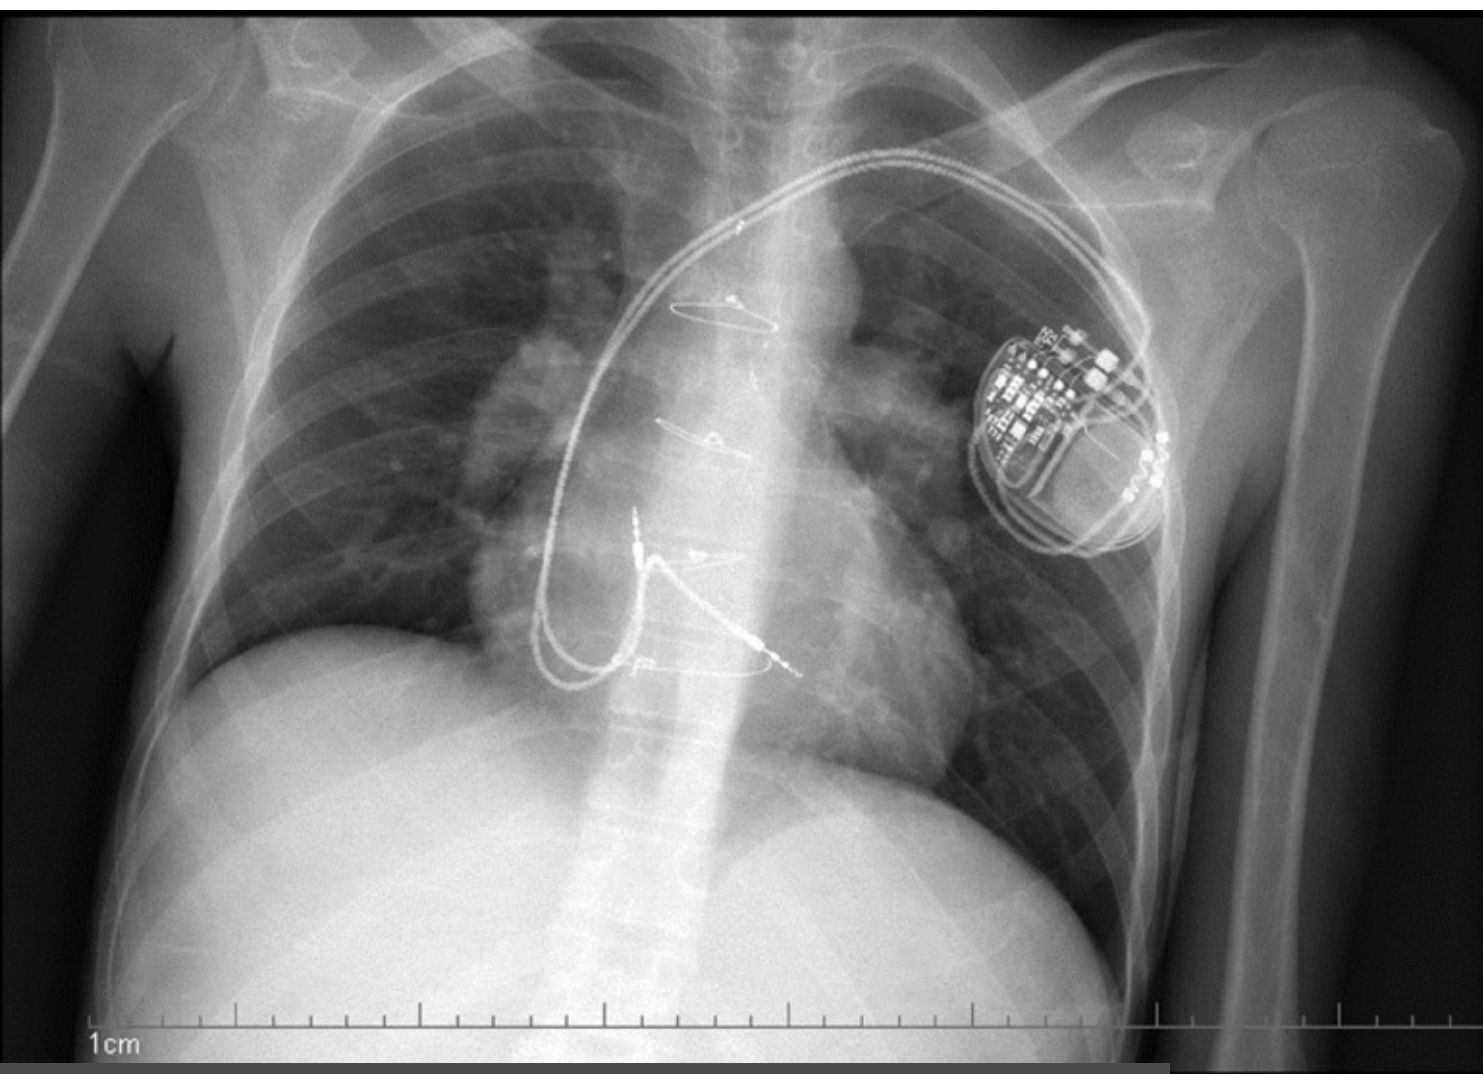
Radiography of epicardial dual chamber pacemaker in pediatric patient
